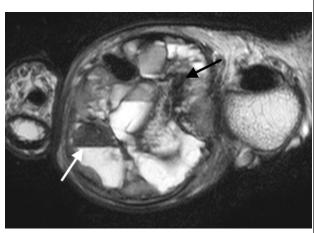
Giant cell tumor with secondary aneurysmal bone cyst transformation. Axial T2W magnetic resonance imaging shows a giant cell tumor involving the second metacarpal bone with internal fluid-fluid levels (white arrow) suggestive of aneurysmal bone cyst transformation. Low signal soft tissue component of the giant cell tumor (black arrow) is also well seen.
